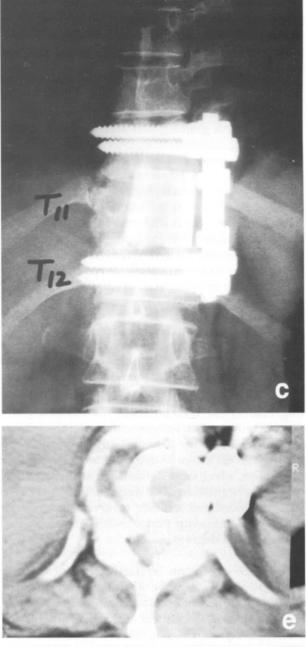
A flexion-compression fracture of T11 with retropulsion of bone into the spinal canal. (a) A lateral film shows severe wedging of the T11 vertebral body. (b) Magnetic resonance imaging shows the retropulsion of bone into the canal. (c) Postoperative anteroposterior and (d) lateral films show a femoral allograft and anterior instrumentation used in the reconstruction of the fracture after anterior decompression via an anterolateral approach. (e) The reconstruction as seen on computed tomography scan.
